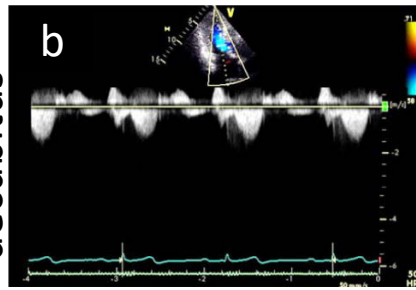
Two-dimensional and continuous-wave Doppler echocardiographic studies in case 1 (A-E) and case 2 (F-J). Apical long-axis views of at rest in case 1 (A) and case 2 (F). In case 1, left ventricular outflow tract flow velocity was increased by Valsalva maneuver in left lateral decubitus position (B -> C), and the phenomenon exaggerated in supine position (D -> E). In case 2, left ventricular outflow tract flow velocity did not change by Valsalva maneuver in left lateral decubitus position (G -> H), but significant increase was observed in sitting position (I -> J).
